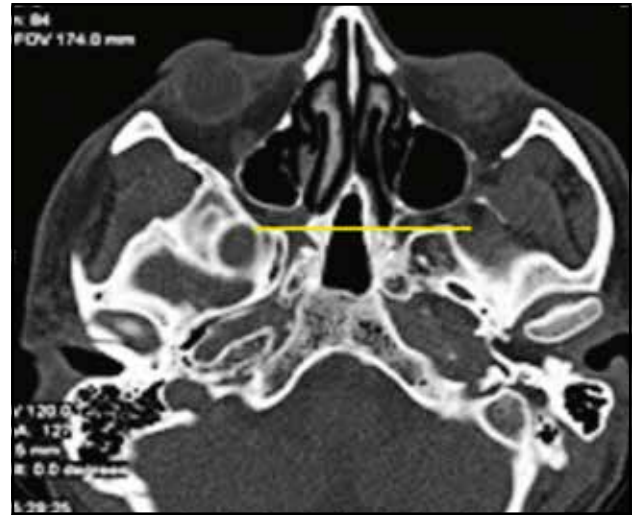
Vomerian extension of the sphenoid sinus (crano-facial CT scan, axial slice).
